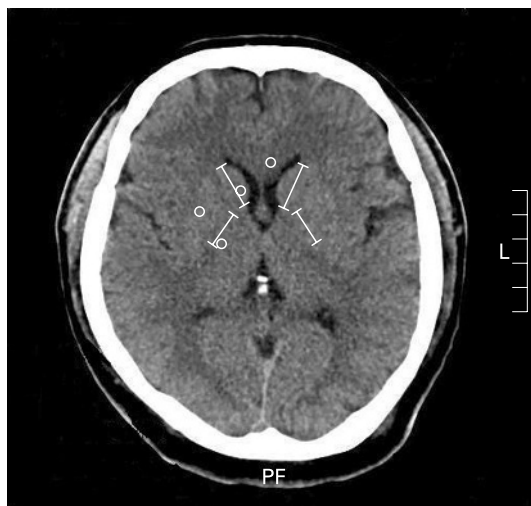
Head computed tomography imaging showing measurements in Hounsfield units at the basal ganglia level, in which the caudate nucleus, internal capsule, genu of the corpus callosum and sylvian fissures are all well visualised. ○, circular regions of interest (10 mm²) positioned in the caudate nucleus, putamen, posterior limb of internal capsule and genu of the corpus callosum.
